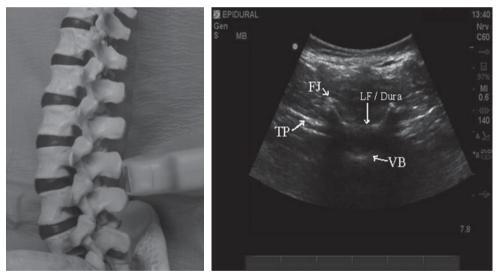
(a) Probe position as related to the bony spine to give the ultrasound image seen in (b). (b) Typical image seen with ultrasound in the transverse plane. Reproduced with the permission of *CPD Anaesthesia* (www.rila.co.uk).
